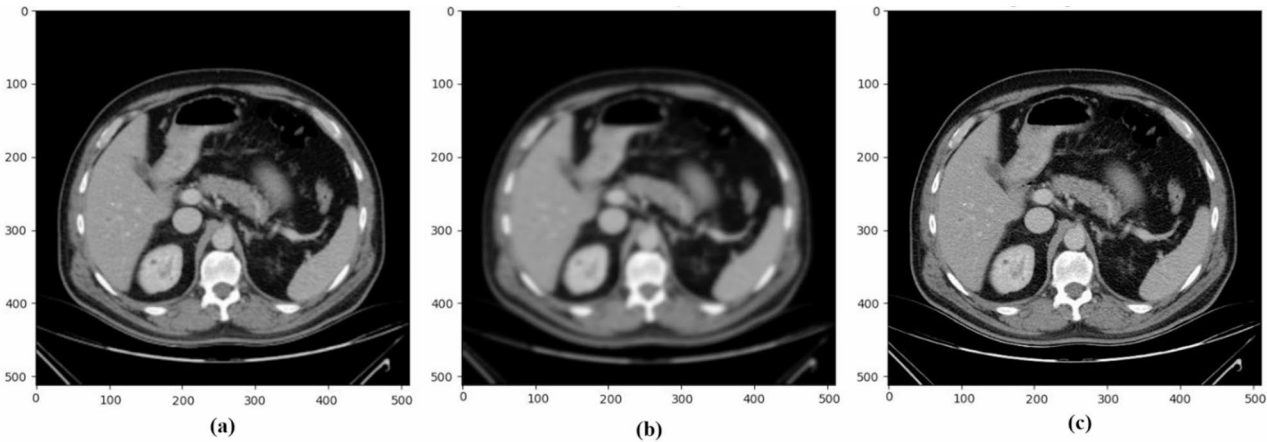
Demonstration of noise reduction using DnCNN-SR: (a) Low-resolution CT image, (b) CT image processed using DnCNN-SR for noise reduction, and (c) Original high-resolution CT image for comparison.
